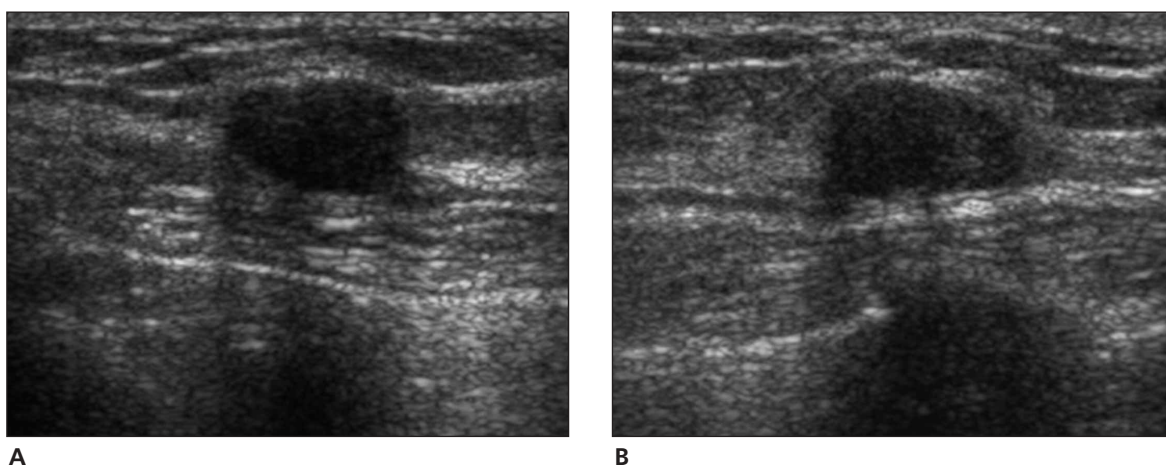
Images from a 42-year-old female patient with a well-defined hypoechoic ovoid lesion on sonography. All 3 reviewers classified it as category 3. After CI revealed that the patient had lesion palpability, the 3 reviewers evaluated this lesion as category 3, 4a, and 4a, respectively. The lesion was proven to be a fibroadenoma at biopsy. A, Transverse plane. B, Longitudinal plane.
